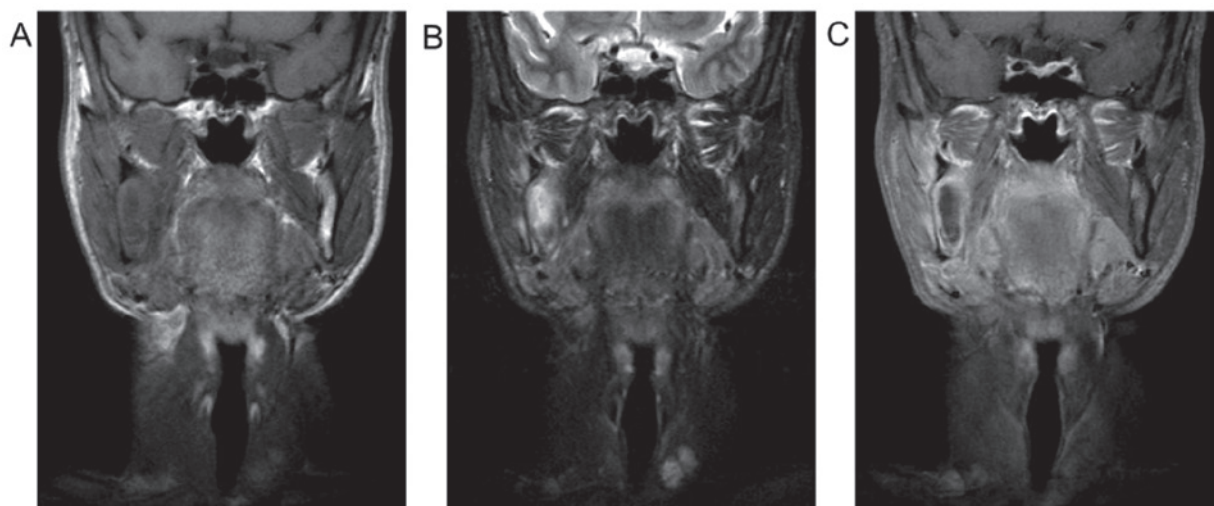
MR images of mandibular lesion. (A) T1WI, homogeneous low to slightly high SI. (B) STIR showed high to markedly high SI indicated cystic area inside the lesion. (C) CE-T1WI demonstrated tight strong enhancement of wall and weak enhancement inside the lesion.
